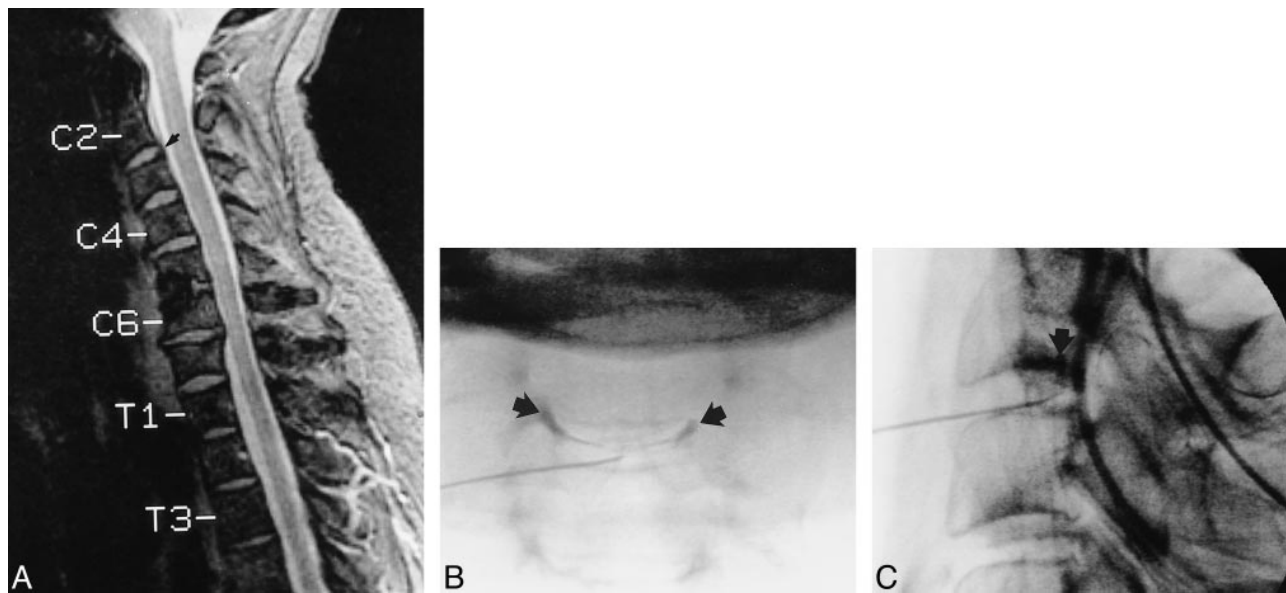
Patient with 9/10 concordant bilateral neck, CVJ, and occipital head pain with slightly abnormal C2–C3 disk contour at MR imaging.
